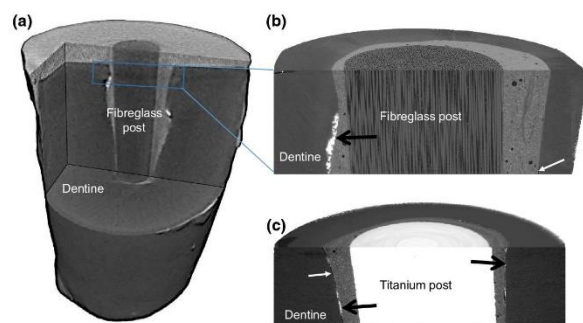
Low-resolution Laboratory μ CT images versus high-resolution PCE-CT: (a) Laboratory μ CT is useful for scans of the entire root, containing the region of interest (e.g. blue marked box) at moderate resolution. High-resolution scans by PCE-CT provided sub-micrometer resolution data of teeth restored with (b) fibre and (c) titanium posts. Note the impressive contrast and high level of detail. White arrows identify voids between dentine and cement. Black arrows show remnants of endodontic sealer.
